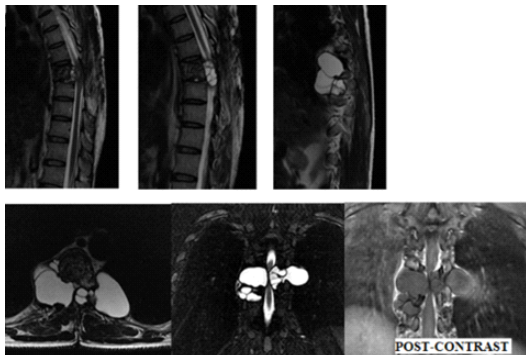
40 year old male patient with history of back pain, MRI of cervico-dorsal spine reveals, multi-loculated cystic lesion involving the extramedullary and extradural location - Spinal hydatidosis.
